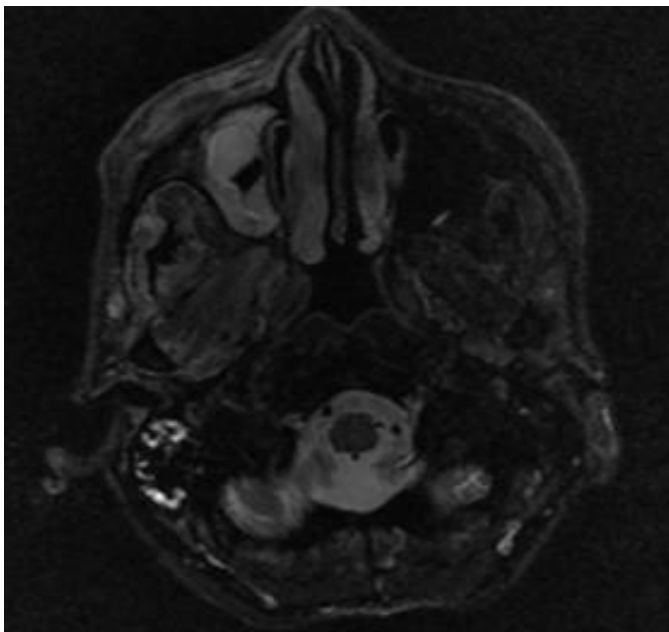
Axial T2 Fat sat. MR image demonstrates mucosal thickening along the right maxillary sinus. There is evidence of stranding along right preantral and retro-antral fat pads. Fat stranding is also noted in Right masticator space and right infratemporal fossa.
